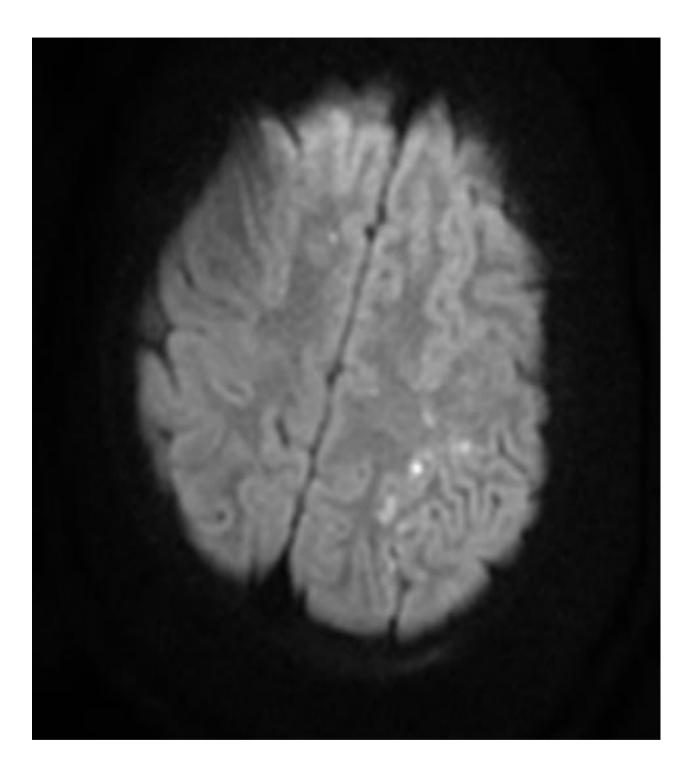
Axial MRI brain demonstrates DAI in left parietal lobe.
